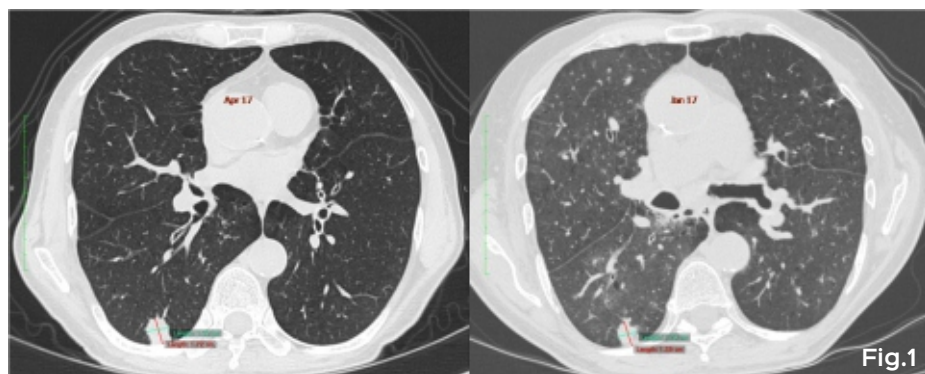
A single 14 mm sized nodule is seen in the superior segment of the right lower lobe. As per the guidelines, either a biopsy work-up or PET/CT or a follow up scan after 3 months would be appropriate. It was decided to follow-up the patient. The repeat study showed increase in the size of the nodule to 16 mm. A CT guided core biopsy was performed which showed adenocarcinoma.
